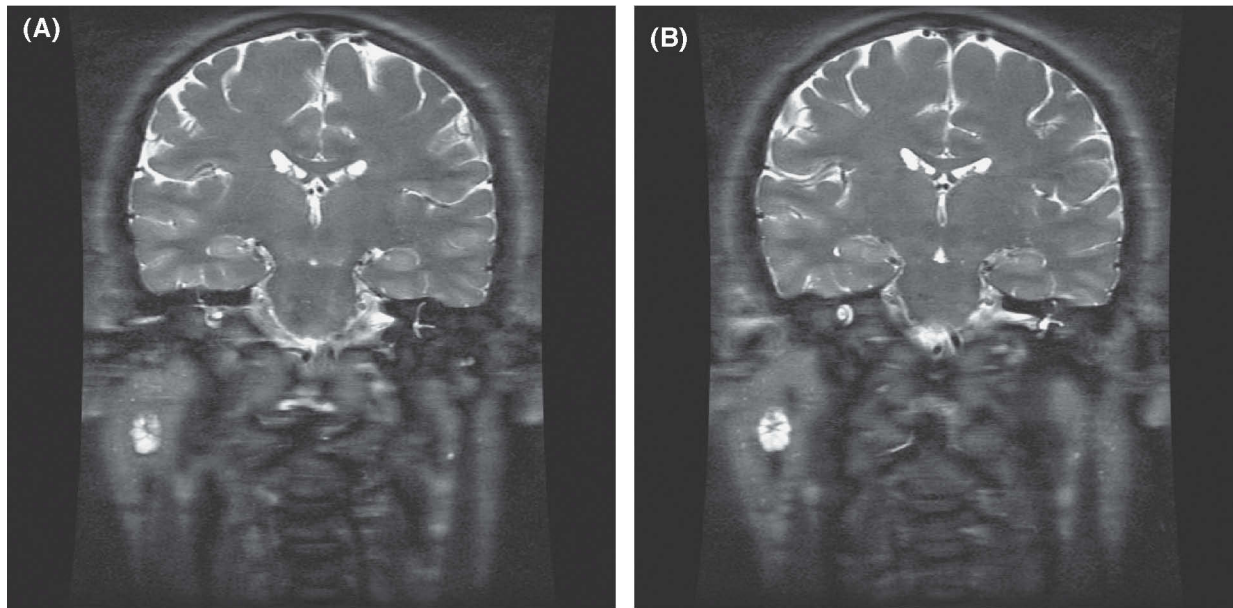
T2-weighted coronal sections of MRI scan showing enlarged parotid glands with small millimetric hyperintense images that may correspond to small cysts or acini, plus a more prominent one (1.3 cm) with a lobular aspect in the right parotid gland.
